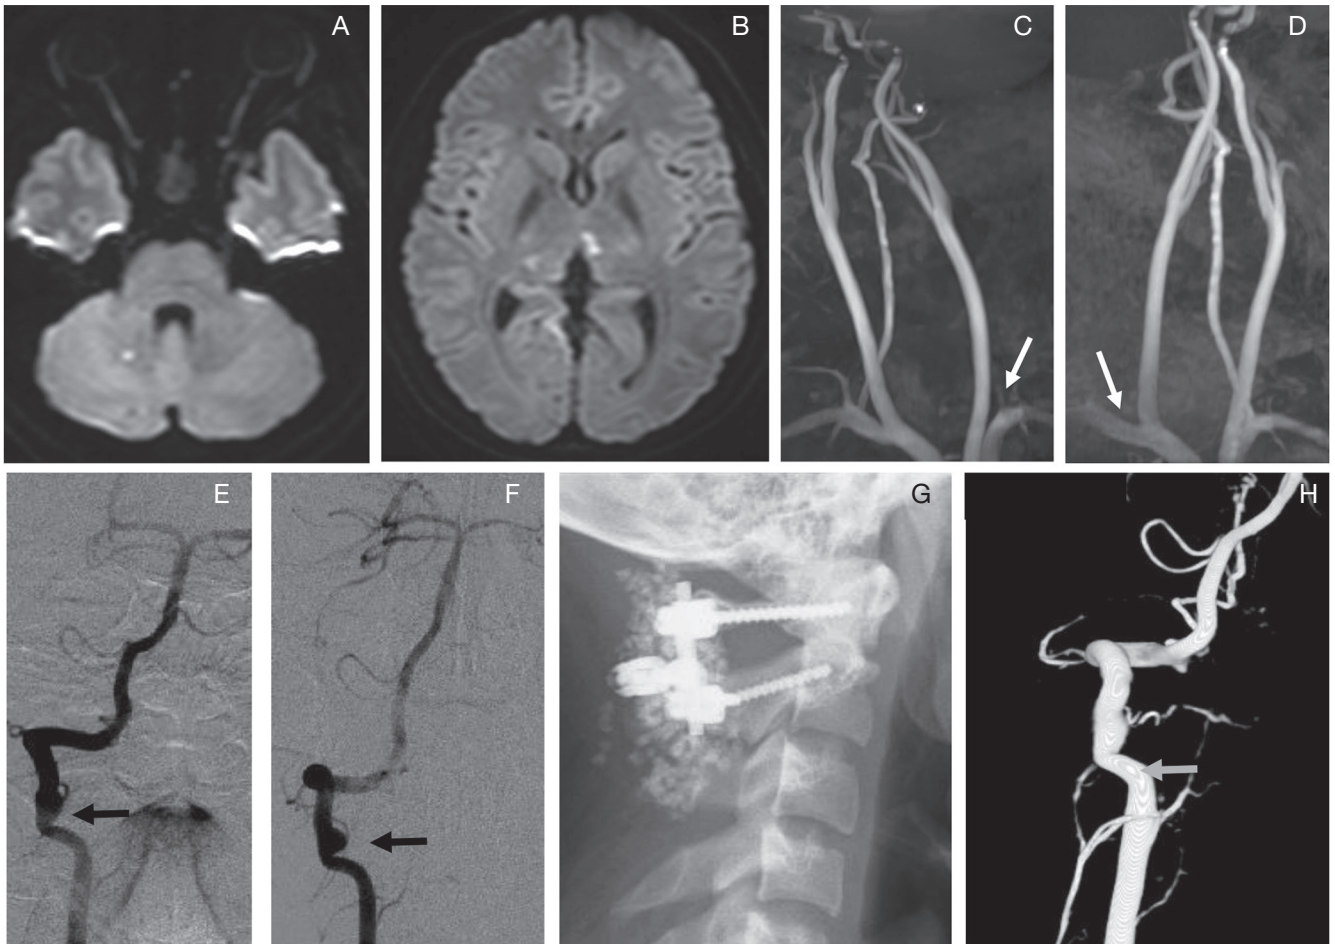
Neuroimaging in case 1. A, B: Magnetic resonance imaging showing multiple high signal intensity spots on a diffusion-weighted image. C, D: Magnetic resonance angiography demonstrated occlusion of the total course of the contralateral vertebral artery (VA) during neck rotation (*arrows*). E: Angiography shows right VA dilatation just distal to the axis of the transverse foramen, suggestion dissection (*arrow*). F: Repeat angiography after 3 months shows exacerbation of VA dissection (*arrow*). G: Postoperative cervical X-ray film demonstrating screws inserted for C1–2 posterior fixation. H: Postoperative vertebral angiography showing improvement of dissection.
